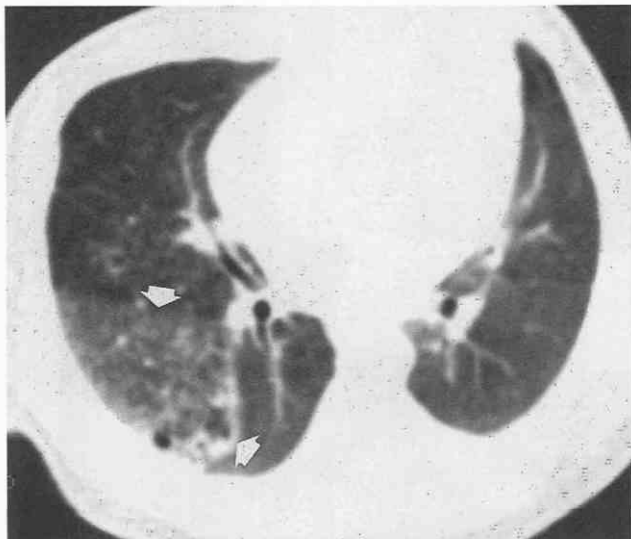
Type 2 congenital cystic adenomatoid malformation in a 2-day-old boy. CT scan shows abnormal density and lucency within the right lower lobe (arrows). The diameters of the small air-filled cystic structures within the mass are smaller than the spaces between normal interstitial markings, differentiating this congenital cystic adenomatoid malformation from congenital lobar emphysema.
